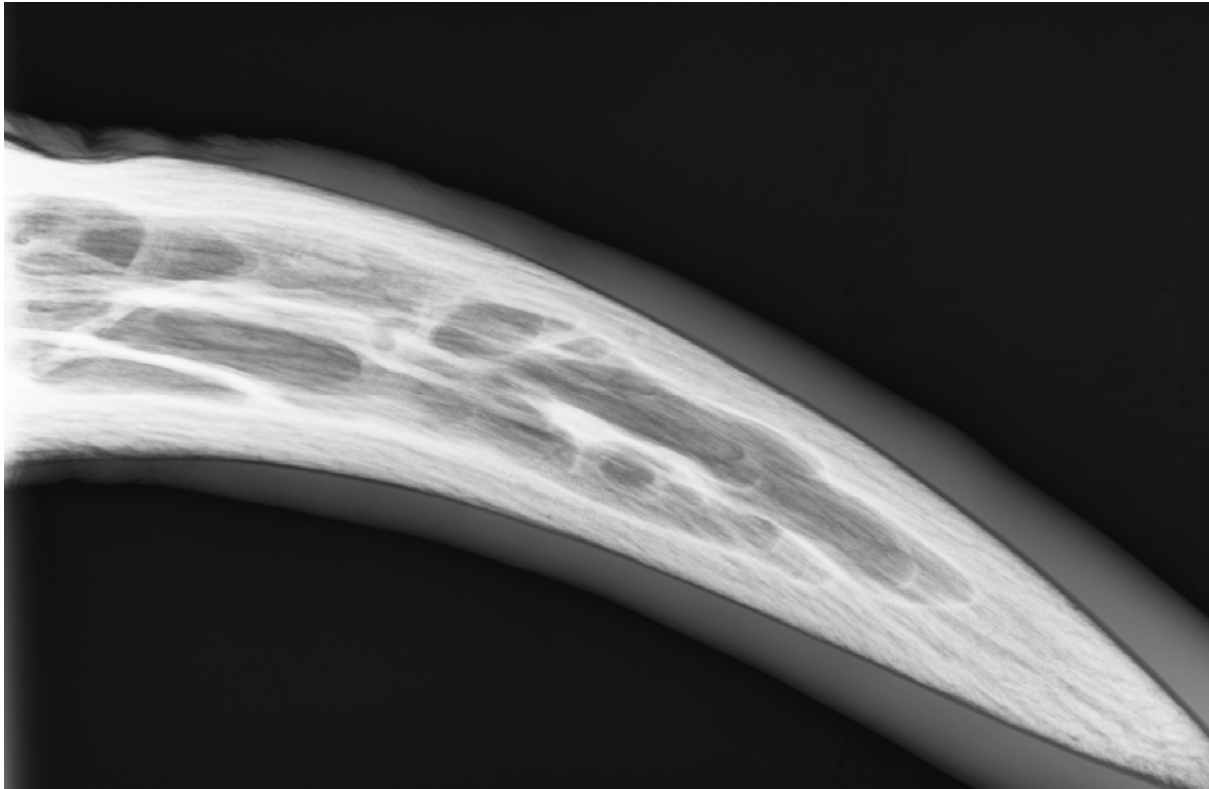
radiograph of ring depression in the left horn of a feral bull from Chillingham Park.
